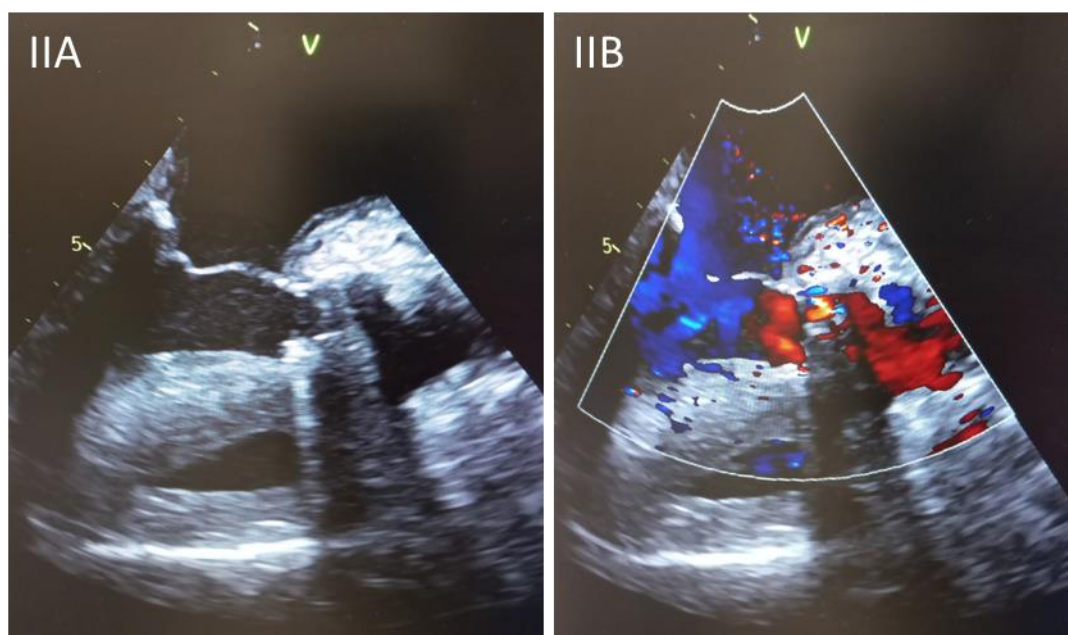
IIA: Intraoperative transesophageal view at 120 degree showing well seated aortic medical prosthesis. IIB: Intraoperative transesophageal view at 120 degree with superimposed Color Doppler showing normal flow through a surgically implanted mechanical aortic prosthesis.
